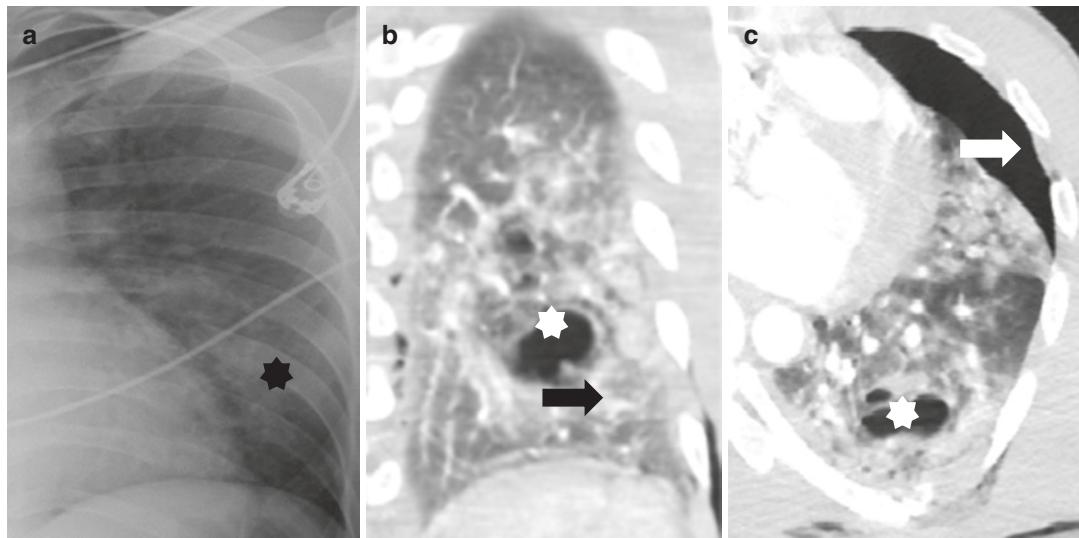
Twenty nine-year-old man presenting after motorcycle collision. Chest radiograph (a) shows left basilar opacity (asterisk), suggestive of pulmonary contusion in the setting of trauma. Coronal (b) and Axial IV (c) contrast-enhanced CT images demonstrate left-sided
